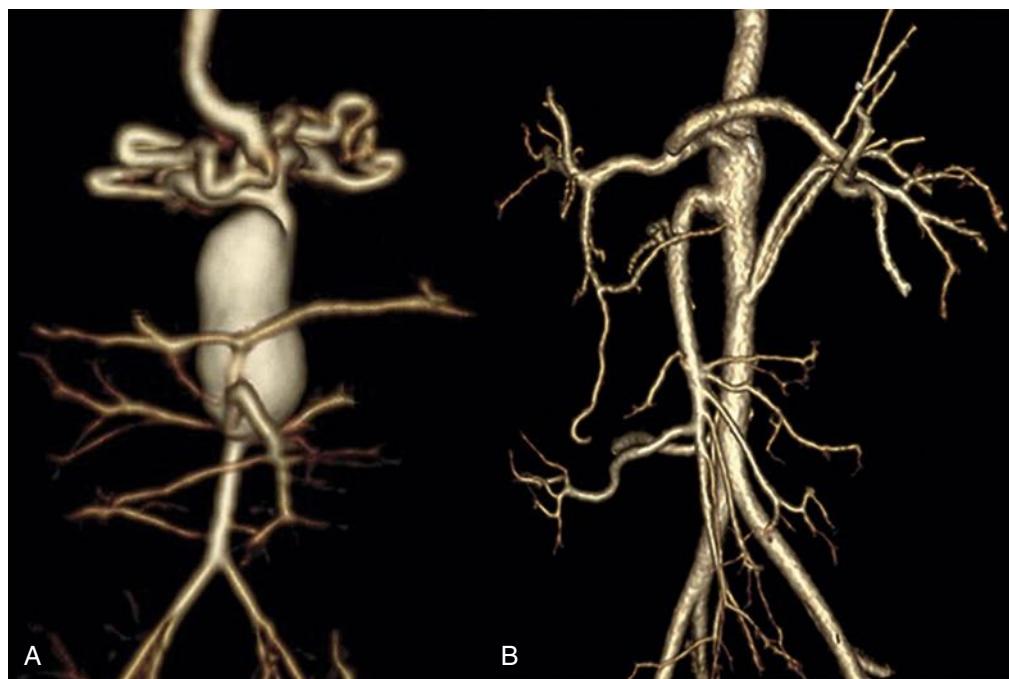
(A) Saccular supraceliac abdominal aortic aneurysm with involvement of the celiac, superior mesenteric, and renal arteries associated with focal and nearly complete occlusion (coarctation) of the diaphragmatic aorta in a 6-month-old (computed tomography angiography). (B) Appearance following resection of the coarcted aortic segment with primary aorto-aortic reanastomosis, open aneurysmorrhaphy, and aortic reimplantation of one of the affected arteries with no evidence of progressive aortic dilation 7 years postoperatively. (From Eliason JL, Coleman DM, Criado E, Stanley JC. Surgical treatment of abdominal aortic aneurysms in infancy and early childhood. *J Vasc Surg*. 2016;64:1252–1261.)
